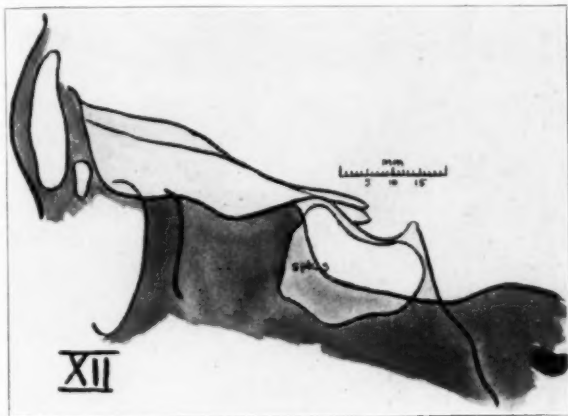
(case 12).—A sketch of the roentgenogram (fig. 36), drawn to scale.
